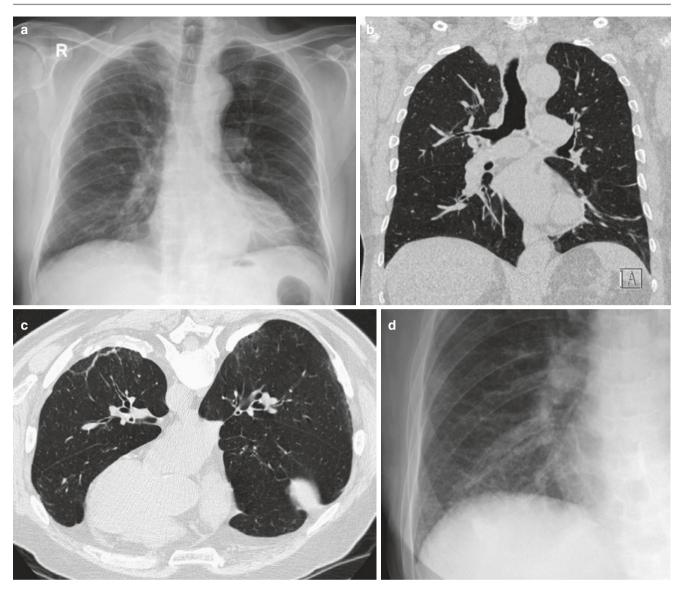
Subsegmental atelectasis. (a, b) Frontal radiograph and CT image show linear bands in the left lung base. (c) Prone CT image shows curvilinear subpleural opacity with pleural plaque in a patient
